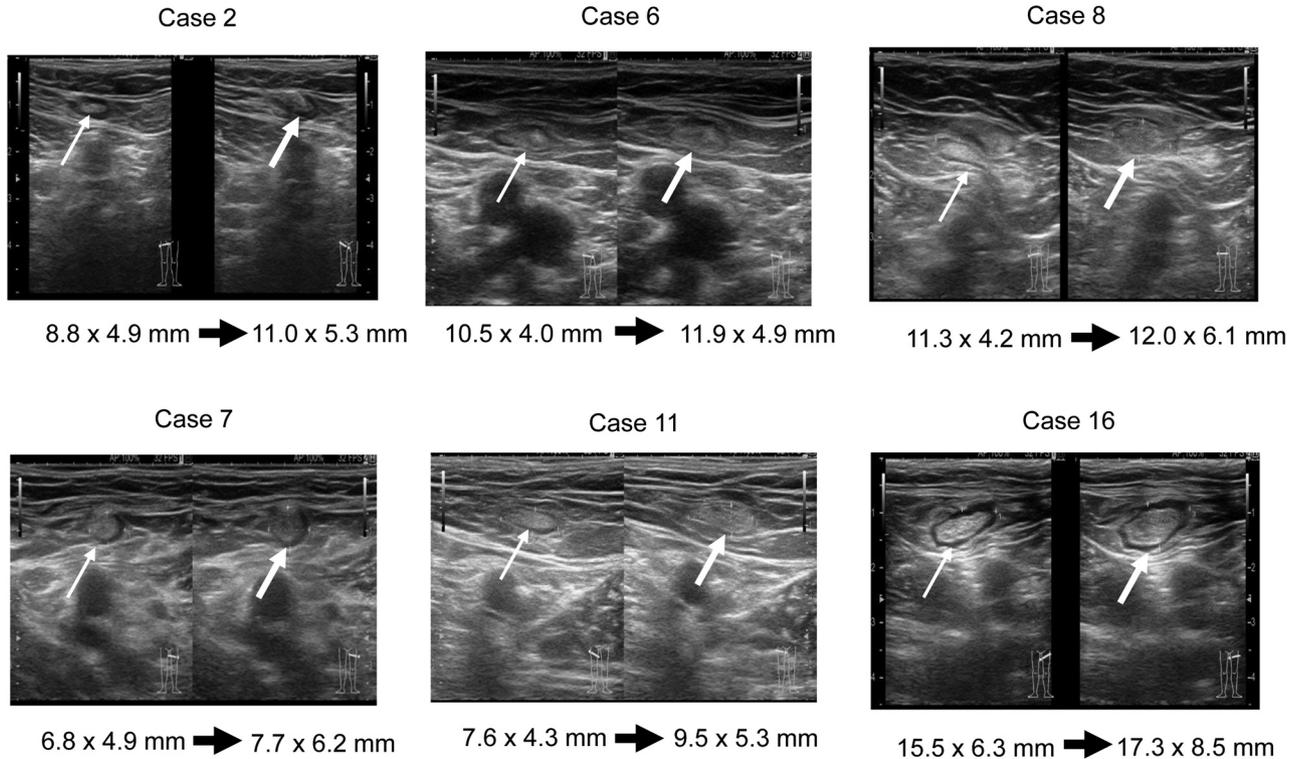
Intranodal administration of DC vaccine. Examples of images of lymph nodes (LNs) before and after intranodal DC vaccine administration. Intranodal administration of DC vaccine into groin LNs using direct ultrasound guidance was provided by a skilled doctor. In each panel, the left side shows LNs before DC vaccine administration, and the right side shows the same LNs after DC injection. Thin-white arrows indicate LNs before vaccine injection. Bold white arrows indicate the LNs after vaccination.
